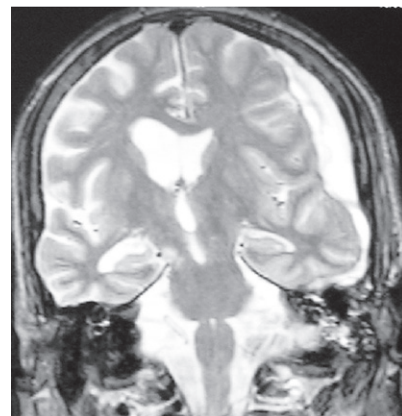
Coronal MRI (T2-weighted image) showing hyperintensity in the region of right crus cerebri opposite the tentorial edge, and left sided SDH
